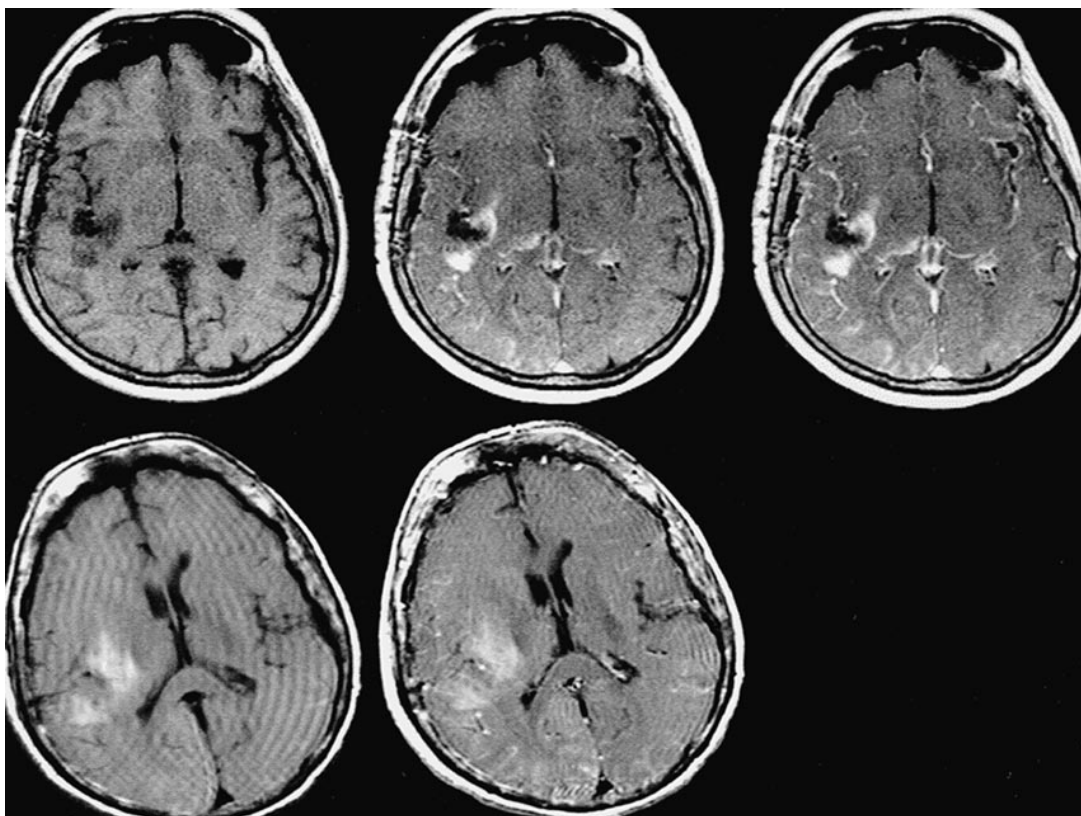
Surgically induced immediate intraparenchymal enhancement. Intraoperative T1-weighted images (*upper row* [from *left to right*], unenhanced and 5 and 20 minutes postcontrast) (532/15/3) show a solid-appearing, intraparenchymal contrast enhancement that shows almost no time dependence. Early (day 1 after surgery) postoperative T1-weighted images (*lower row: left*, unenhanced; *right*, postcontrast) show a intraparenchymal hyperintensity but no contrast enhancement (674/20/2). This type of enhancement probably represents (transient) blood-brain barrier disruption. The hyperintensity on the unenhanced T1-weighted images of the postoperative examination is possibly caused by contrast agent administered intraoperatively, which is "captured" in the tissue after the blood-brain barrier disruption resolves. It is, however, too early to represent methemoglobin.
